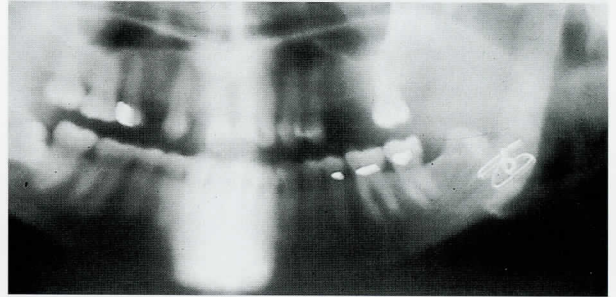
36-year-old patient with diagnosis of ameloblastoma in the left mandibular ramus. In the picture is noticed in the radiographic image after the resection of the affected bone fragment and the reconstruction with the costochondral graft obtained from the sixth right rib and attached to the mandibular body with osteosynthesis plates (case 3).
